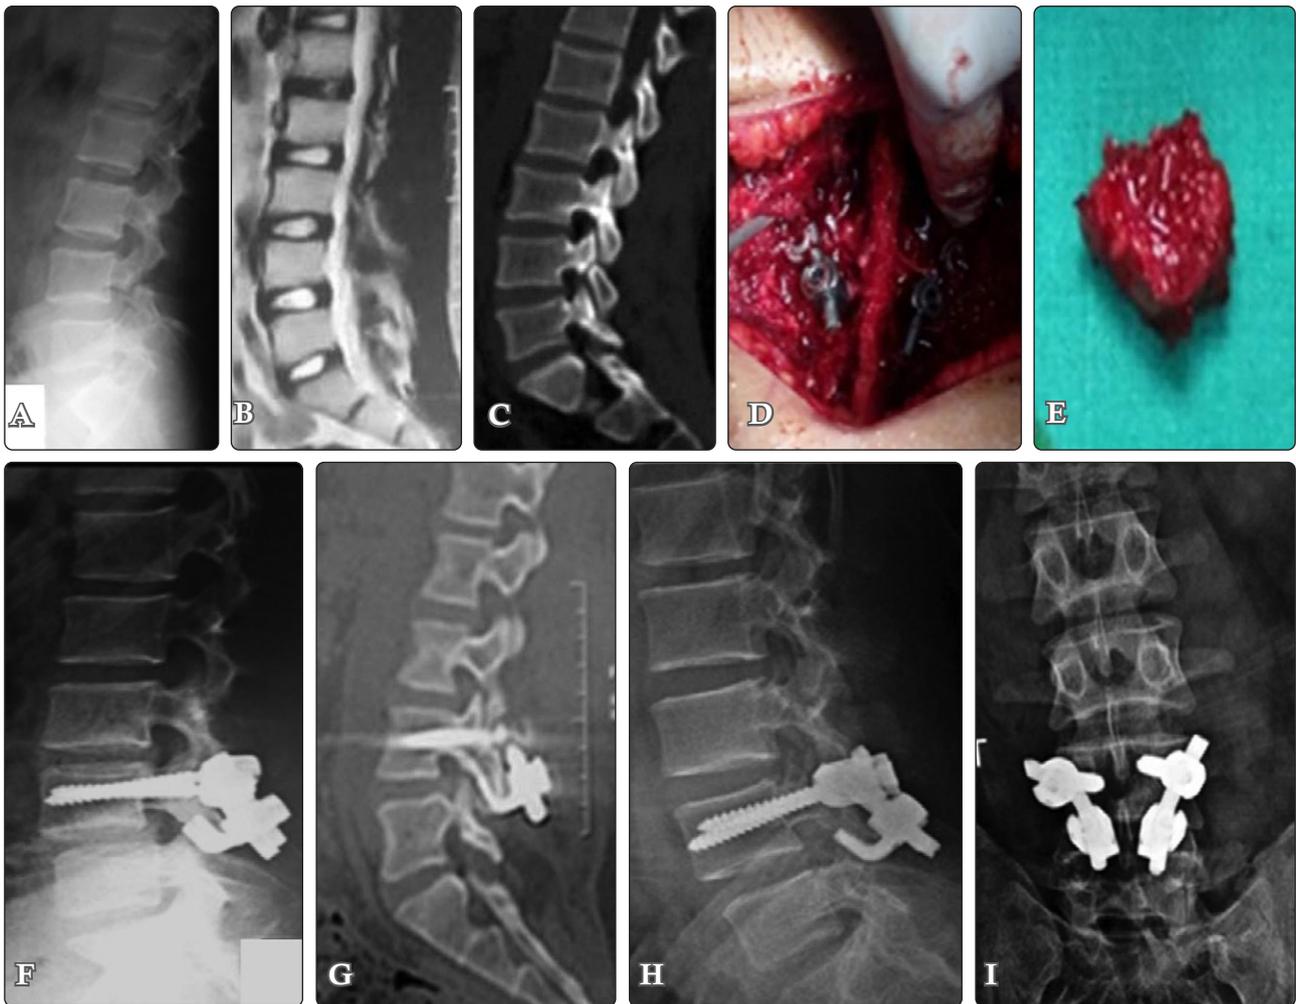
A 15-year-old male patient with persistent low back pain. Preoperative (A) plain lateral view radiograph showing L4 pars defect. (B) Sagittal T2 WI MRI showing intact disc space. (C) MSCT-scan sagittal reformate showing L4 pars defect. (D) Intraoperative photo demonstration of the procedure. (E) Iliac crest graft used. (F) Postoperative lateral radiograph. One year postoperatively, (G) MS SC-Scan sagittal reformats. (H) Lateral radiograph. (I) Anteroposterior radiograph showing pars healing.
